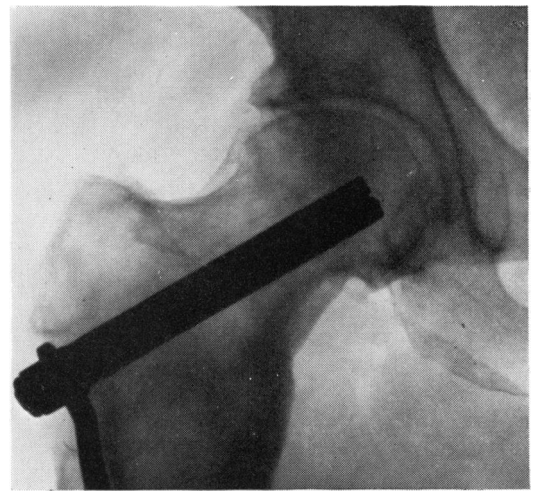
A radiograph taken nine months later. The marked regression seen in this film has been fully maintained over a further three years*
